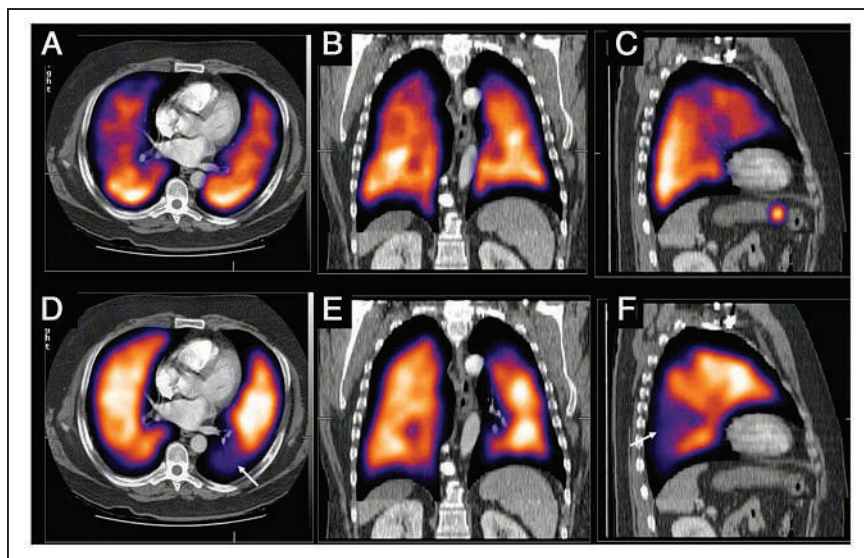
Representative SPECT/CT images of lung ventilation (top) and perfusion (bottom) demonstrating segmental perfusion defect (arrow in D and F) in left lower lobe with no CT opacity or matched ventilation defect consistent with pulmonary embolism. (Reprinted from (3).)
